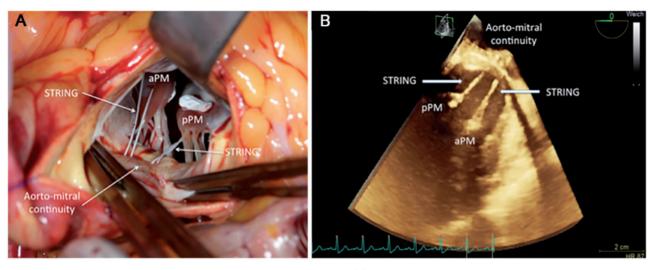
Intraoperative and echocardiographic image of the RING + STRING procedure. (A): intraoperative view via horizontal aortotomy: 2 polytetrafluoroethylene (PTFE) sutures ('STRING') anchored in heads of both papillary muscles (aPM: anterior papillary muscle; pPM: posterior papillary muscle) and exteriorized through the aorto-mitral continuity. (B): 3-dimensional-transesophageal echocardiography: 2 PTFE sutures ('STRING') anchored in heads of both papillary muscles fixed at the aorto-mitral continuity.
